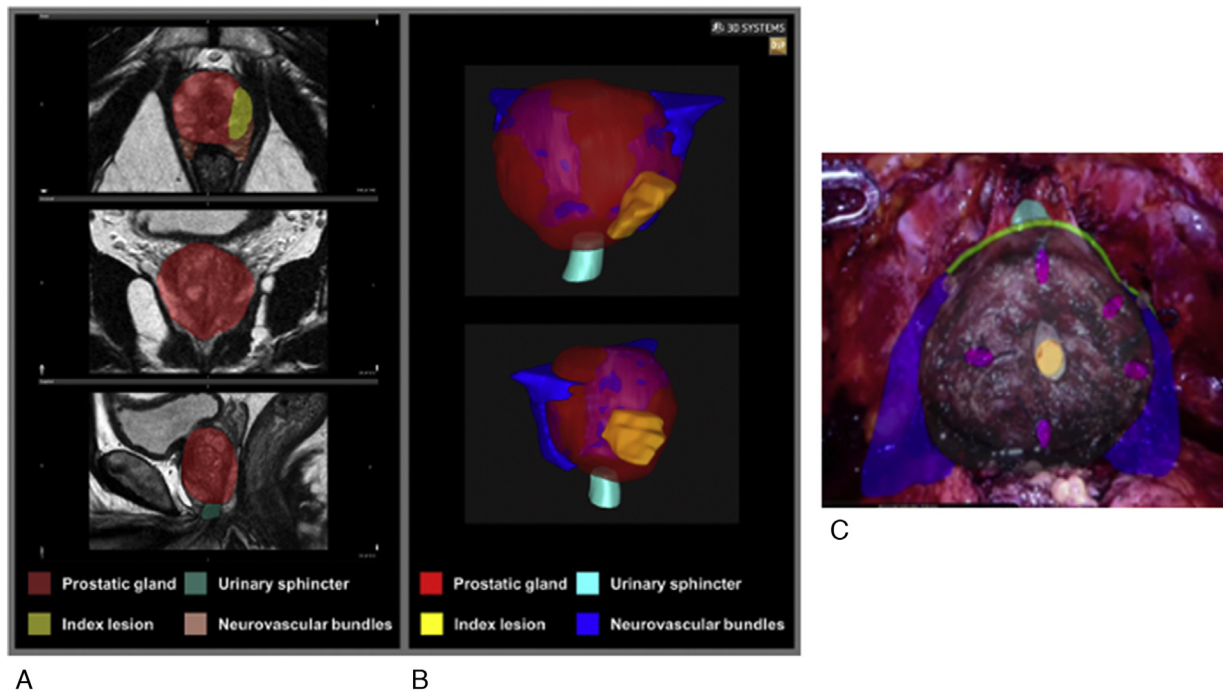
(A) The 3D virtual anatomical model is obtained starting from patient mpMRI, by the segmentation of the anatomical regions of interest (prostatic gland, index lesion, urinary sphincter, and neurovascular bundles) to (B) the final 3D model (C) that is overlapped in the robotic view through the AR technology. AR = augmented reality; 3D = three dimensional; mpMRI = multiparametric magnetic resonance imaging.
